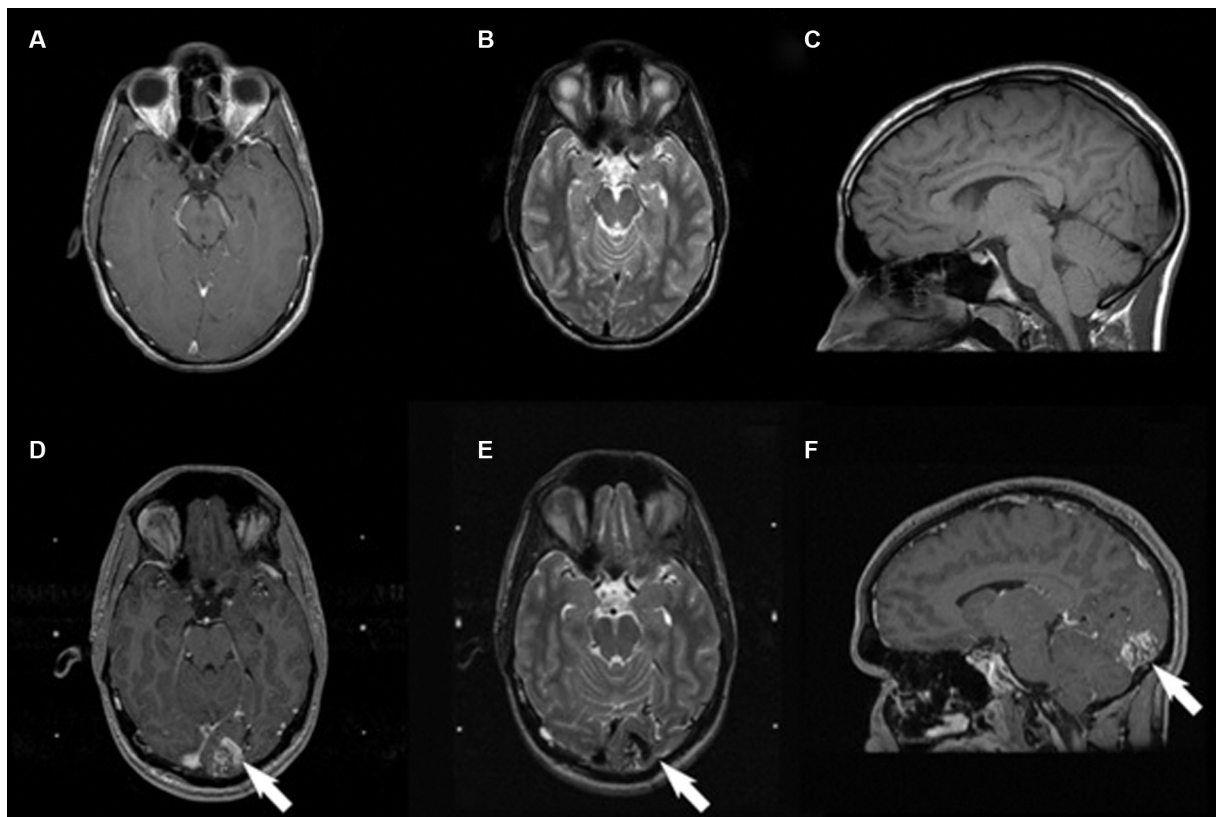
Magnetic resonance imaging findings from initial presentation to second presentation showing de novo formation of a Spetzler-Martin grade 3 left occipital arteriovenous malformation (AVM). Axial T1-weighted image with contrast (A), axial T2-weighted image (B), and sagittal noncontrast T1-weighted image (C) from age 17 demonstrating no evidence of vascular pathology. Axial contrasted T1-weighted image (D), axial T2-weighted image (E), and sagittal contrasted T1-weighted image (F) at age 31 demonstrating a new left occipital AVM (white arrow) denoted by hypointense signal.
